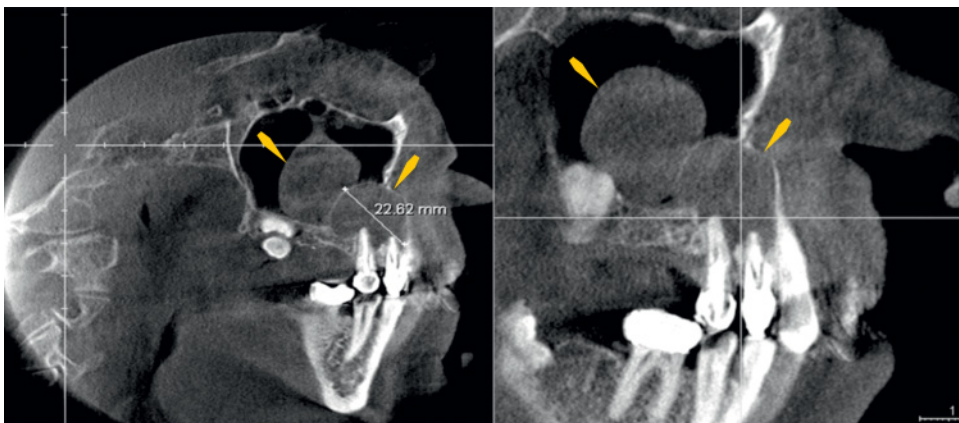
Cone beam computed tomography images of a periapical cyst expanded into the maxillary sinus (right arrows in each figure part), and a sinus "mucocoele" or pseudocyst of the lateral wall of the maxillary sinus (left arrows in each figure part).
